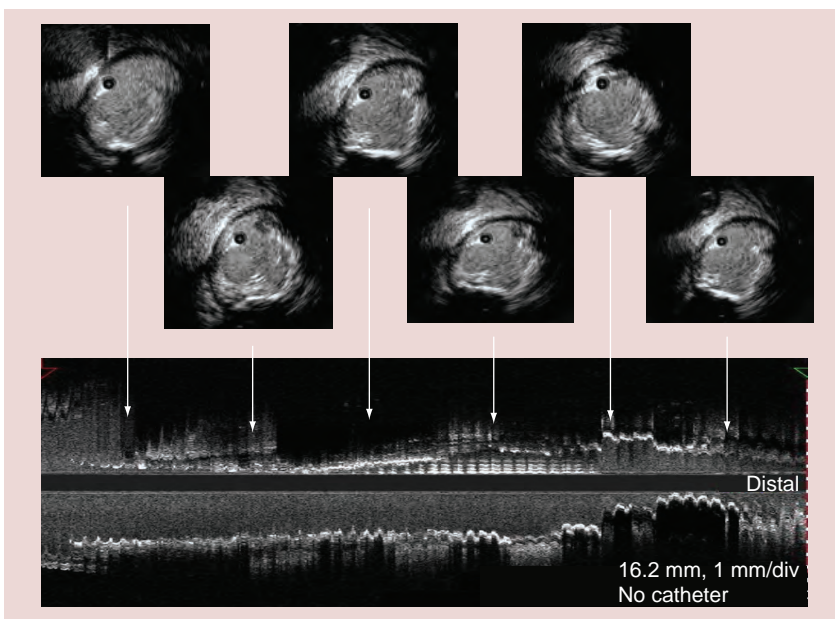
Baseline intravascular ultrasound analysis. Intravascular ultrasound analysis of ectasic left anterior descending coronary artery, showing multiple cavities connected with the lumen with an intraplaque ulceration (arrows: approximate correspondence of the intravascular ultrasound slices with longitudinal reconstruction).
